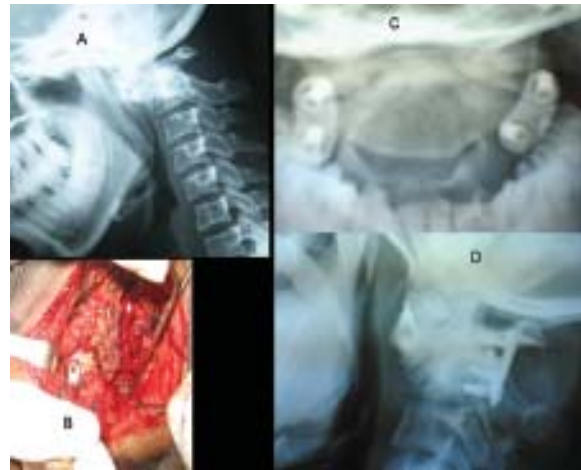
A-X-ray CV junction lateral view showing non reducible AAD, B-peroperative picture of C1C2 lateral mass plate and screw fixation, C-x-ray CV junction open mouth view showing lateral mass plate and screw, D-X-ray CV junction lateral view showing C1C2 lateral mass plate and screw in non reducible AAD with bone fusion.
